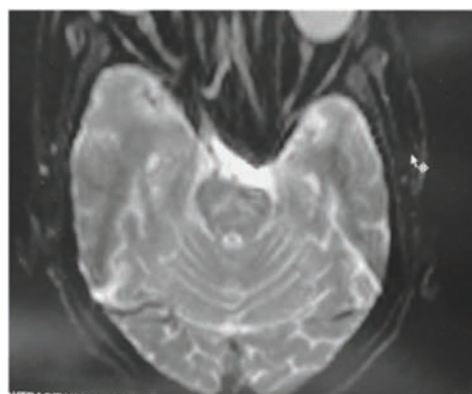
Repeat MRI Brain (T2) showing hyperintensity in the central pons
